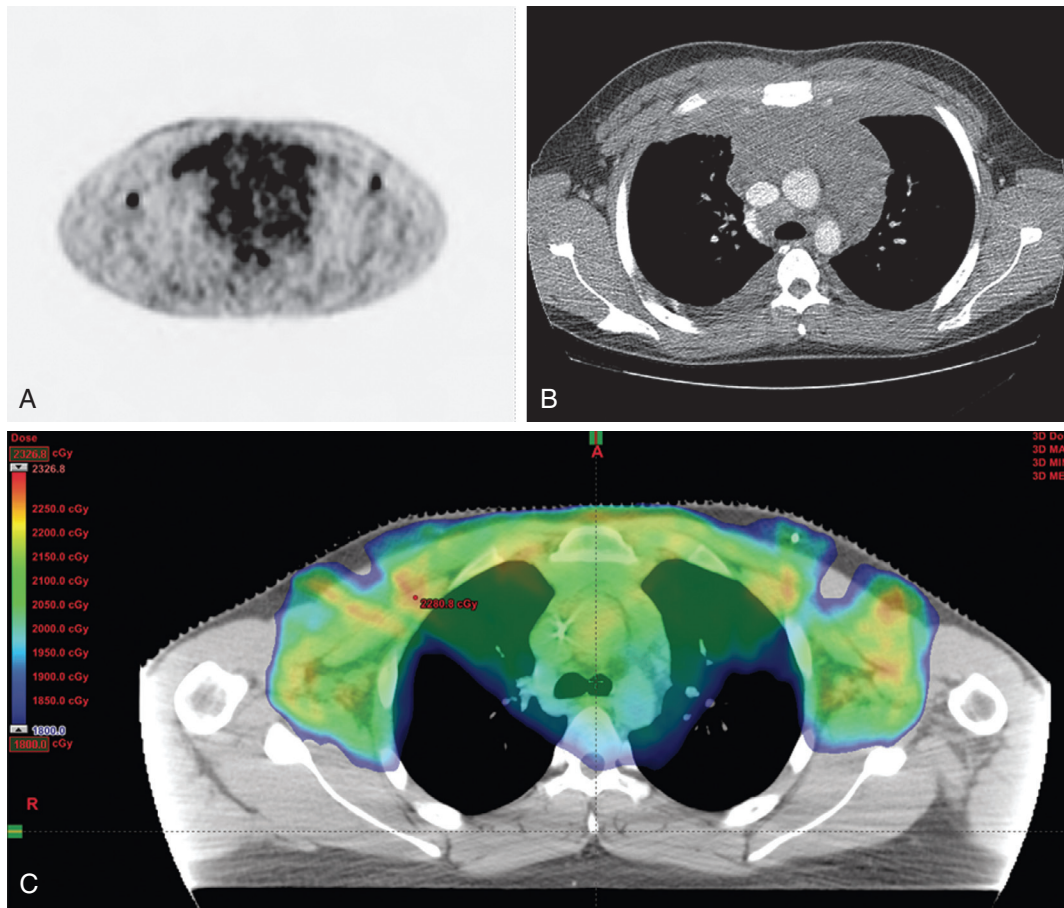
Use of intensity-modulated radiation therapy (IMRT) is not standard in Hodgkin's lymphoma but may be preferred in special circumstances. In this case, IMRT was used to treat extensive anterior chest wall involvement at diagnosis. This 18-year-old male with stage IVB nodular sclerosing Hodgkin's lymphoma presented with fevers, sweats, chest pain, purities, and right supraclavicular adenopathy. Staging showed neck, bilateral axillary, and bulky mediastinal adenopathy. Panel A and B shows extensive anterior chest wall involvement on positron emission tomography (PET) and computed tomography (CT) imaging, respectively. After a complete response to ABVE-PC chemotherapy for four cycles, the patient underwent involved field radiotherapy to 21 Gy in 14 fractions. Standard anteroposterior and posteroanterior (AP-PA) fields would have included too much lung. Instead, an IMRT plan yielded a better dose distribution with lower risk for pulmonary toxicity while insuring good coverage of initial sites of involvement. Panel C shows the IMRT dose distribution in a color wash superimposed on an axial CT scan postchemotherapy at the level of the carina. Two years following therapy, patient remains free of lymphoma and is a competitive swimmer in college.
